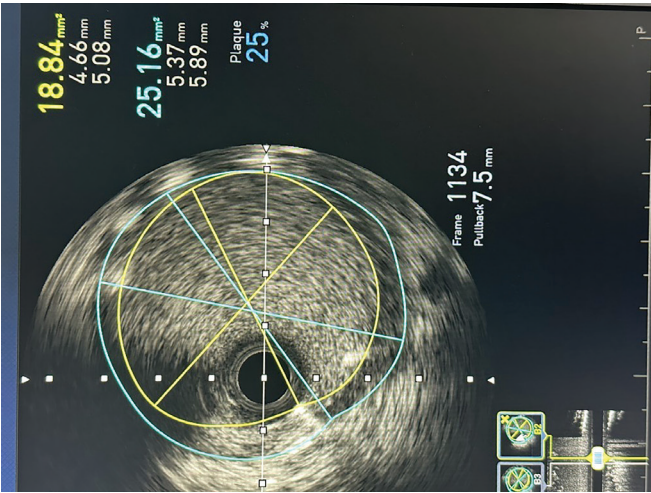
Final IVUS (intracoronary ultrasonography) image
